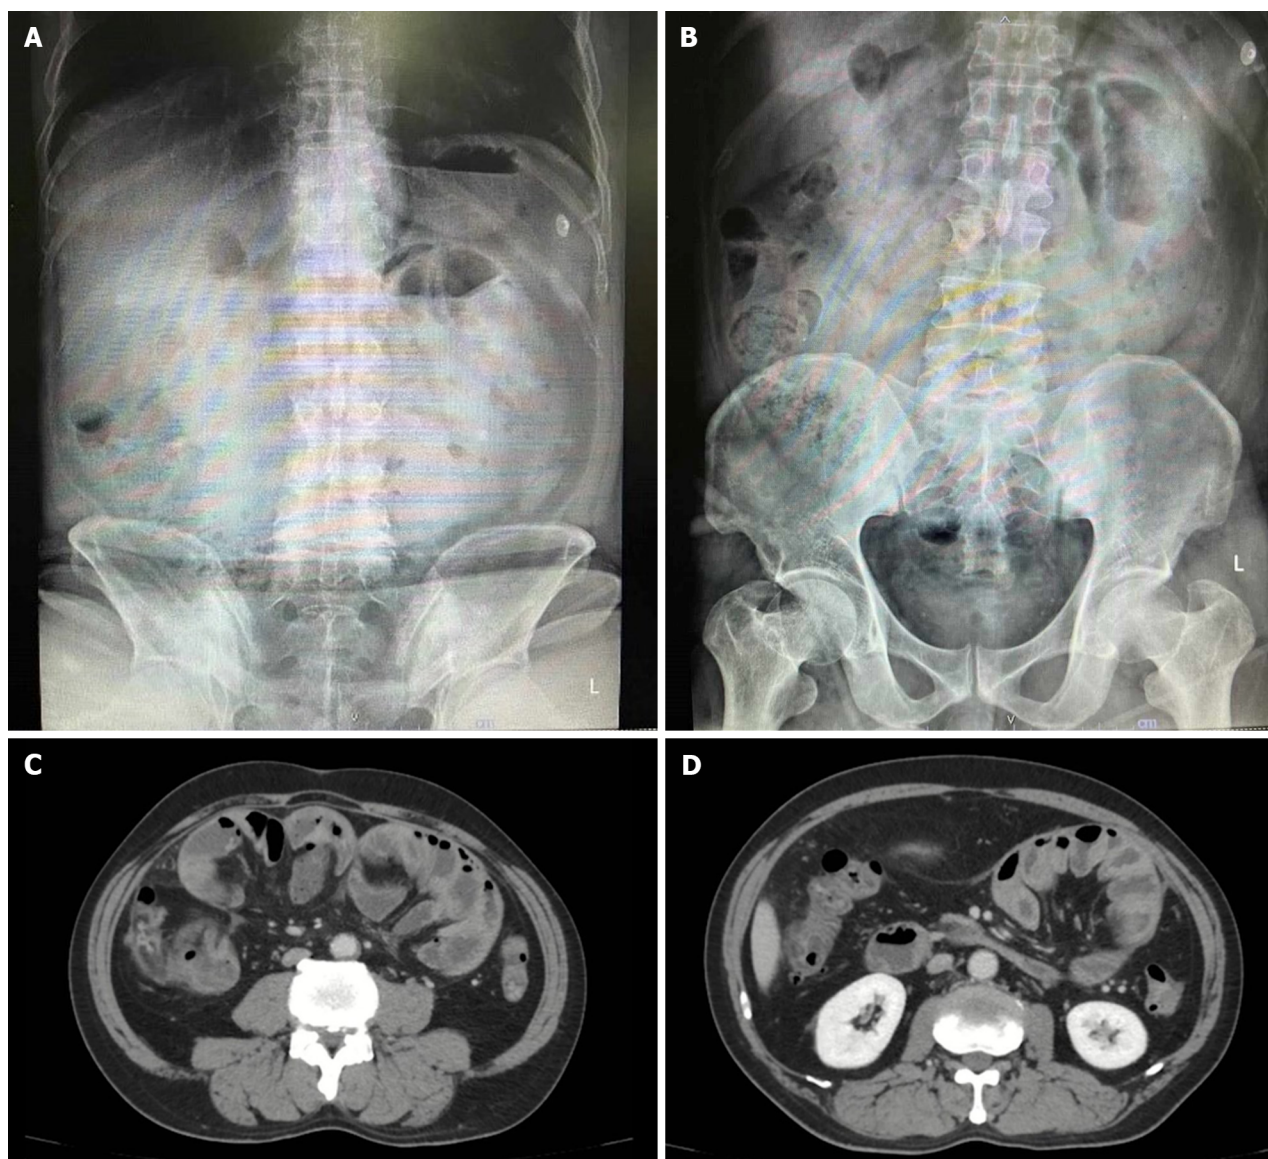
Abdominal X-ray and computed tomography scan whole abdomen with contrast. A: Upright view; B: Supine view; C and D: Computed tomography scan of enhancing peritoneum (cocoon-like) without small bowel dilatation.
